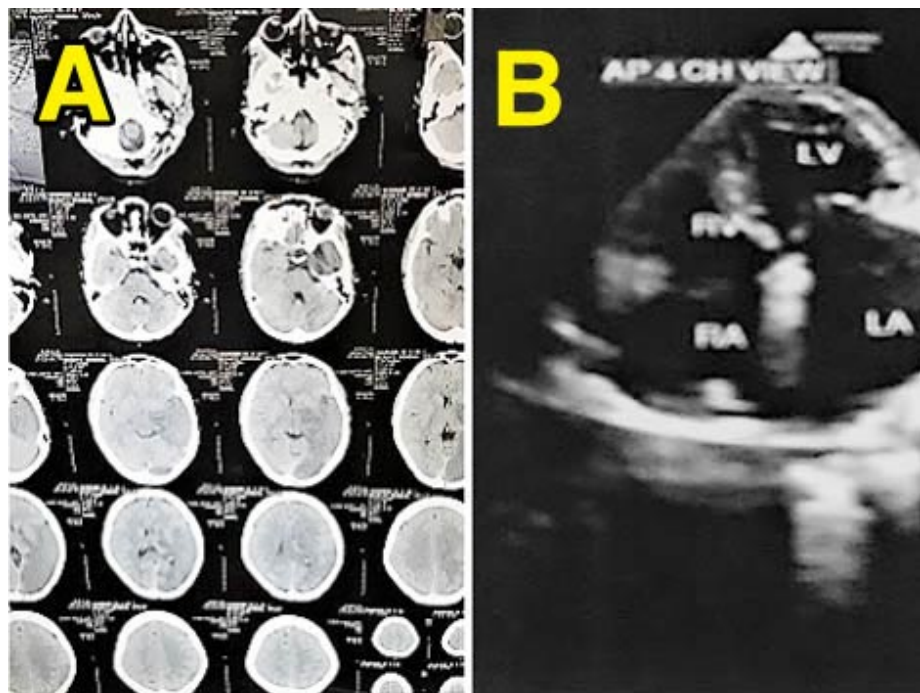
Sister's available imaging reports. (A) CT brain showing left parieto-occipital infarct. (B) Still echocardiographic image showing biatrial enlargement
